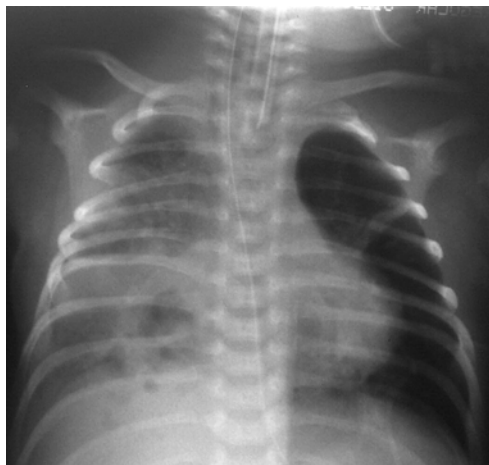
Necrotizing pneumonia. Chest radiograph showing features of consolidation and multiple areas of radiolucent foci without air-fluid levels in the right lung.
